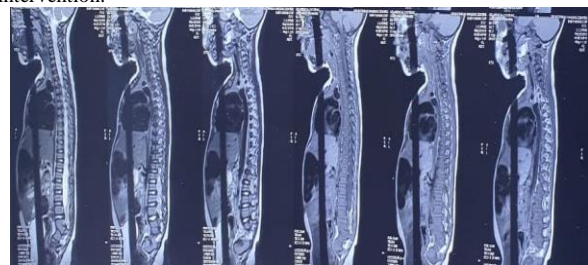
Sagittal section MRI showing absence of caudal sacrococcygeal vertebral segments, cord ending at level
